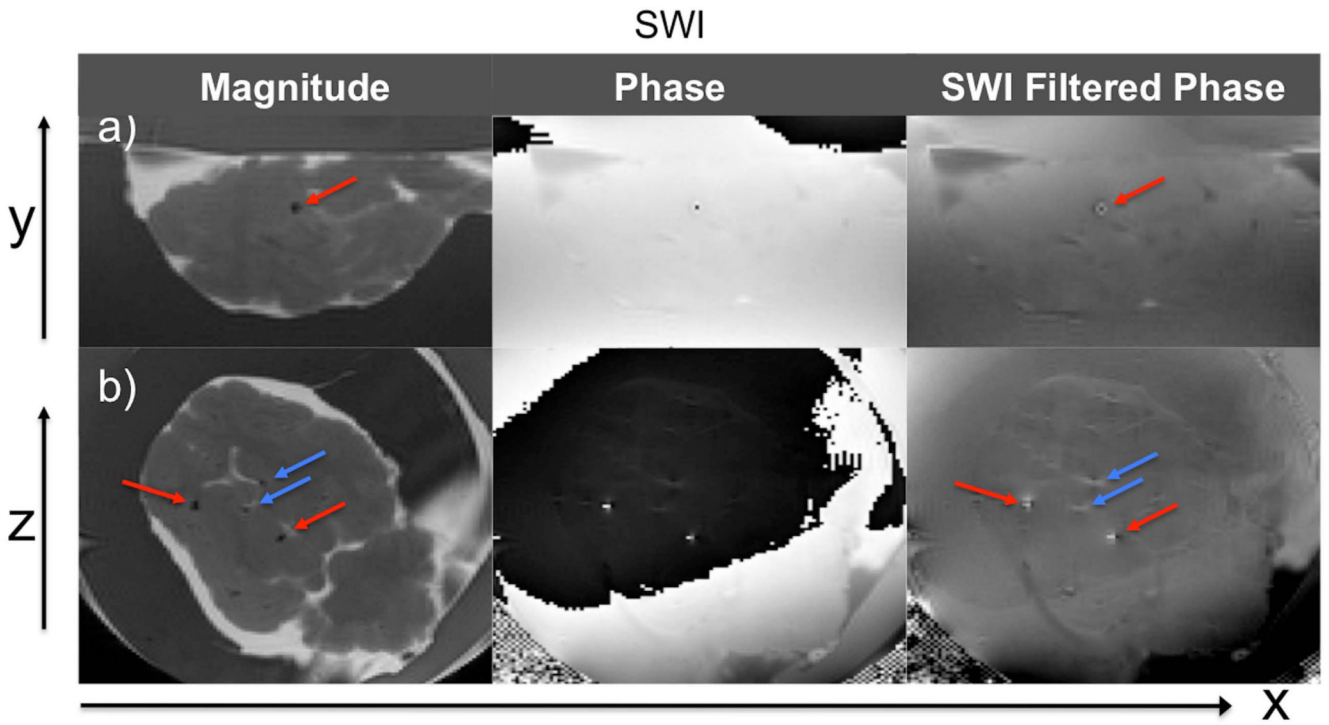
SWI magnitude, phase and SWI filtered phase images in a) x-y and b) x-z planes. Red arrows point to calcifications corresponding with CT images. Blue arrows show hypointense regions due to air bubbles or blood vessels present in the ex vivo brain. Indistinguishable in magnitude images, SWI filtered phase is able to differentiate calcification from air bubbles by opposing field pattern. The same applies to iron containing vessels.
